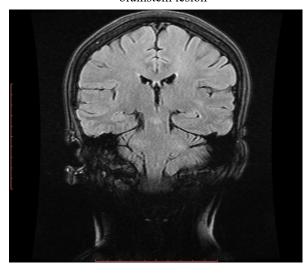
Coronal T2 FLAIR – lesion in the brainstem
